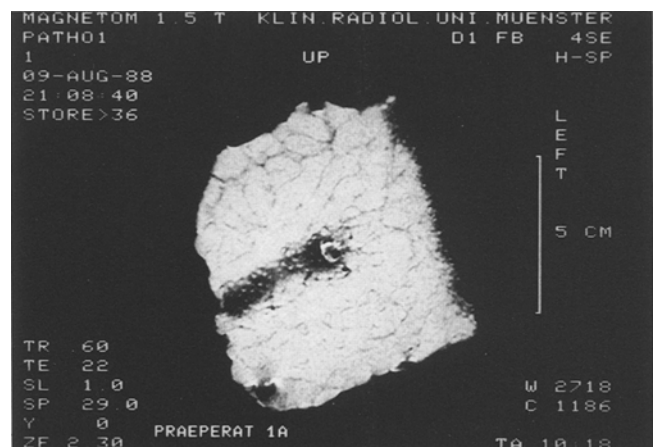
Nuclear magnetic resonance image of a entry wound with ferro-magnetic substances around the perimeter and in the bullet track. Additional loss of signal surrounding the puncture mark of a needle (lower left corner)
